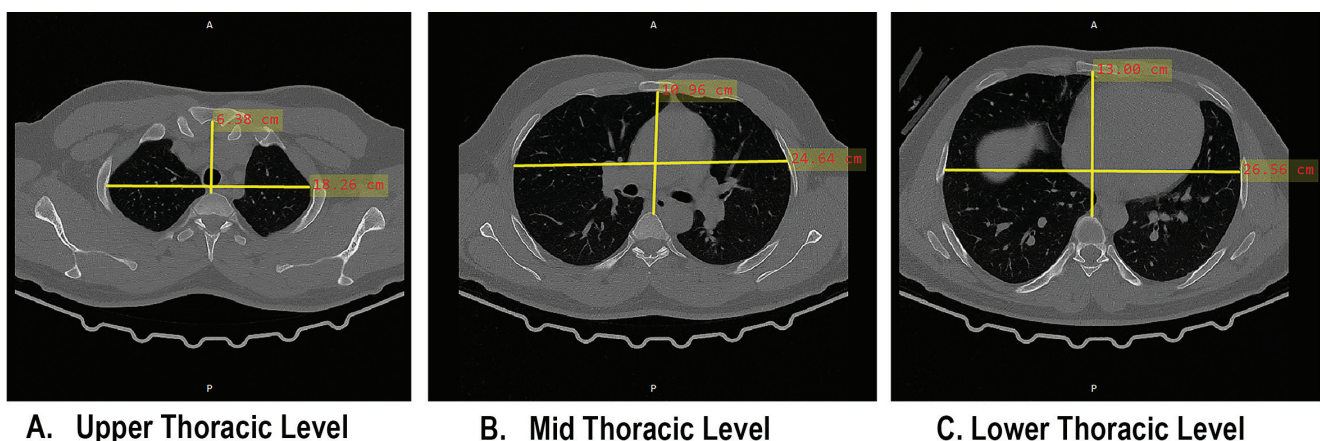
displays chest CT images at different thoracic levels, A. Upper thoracic (T3 level): Measurement of the anteroposterior diameter between the manubrium of the sternum and vertebral body, and the transverse diameter between the inner sides of the ribs. B. Mid thoracic (T6 level): Measurement of the anteroposterior diameter between the body of the sternum and vertebral body, and the transverse diameter between the inner sides of the ribs. C. Lower thoracic (T10 level): Measurement of the anteroposterior diameter between the xiphoid process and vertebral body, and the transverse diameter between the inner sides of the ribs.
